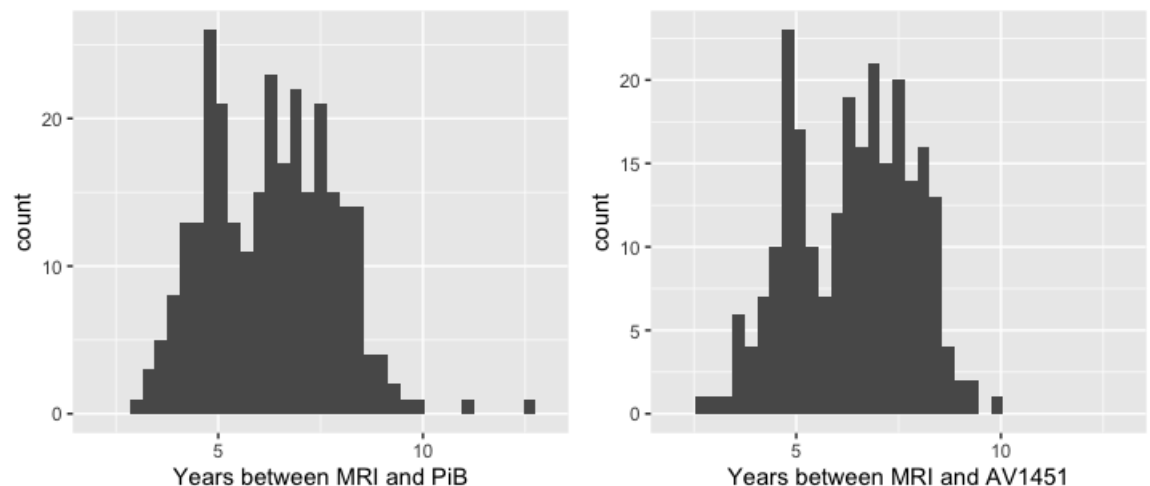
Histogram of years between MRI and PET scans.
